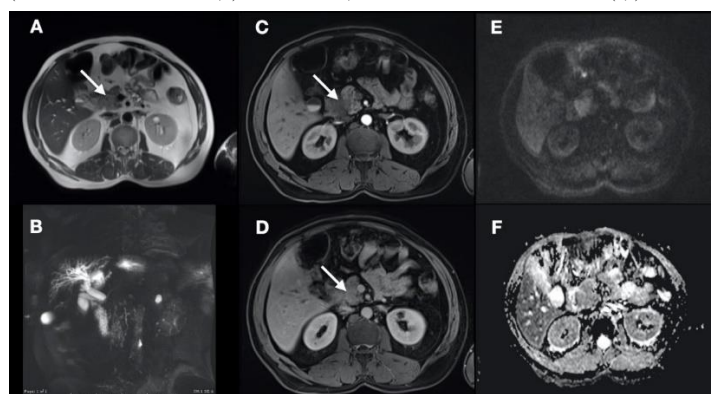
A 58-year-old female patient with poorly differentiated intestinal-type periampullary adenocarcinoma. The lesion was hyperintense (white arrow) on the axial T2-weighted images (a), and MRCP (b) images showed that the common bile duct has an abrupt ending. On contrast-enhanced MRI sequences, the lesion exhibited gradual enhancement (white arrows as shown in c,d). On the DWIs, diffusion restriction was detected (e,f).
